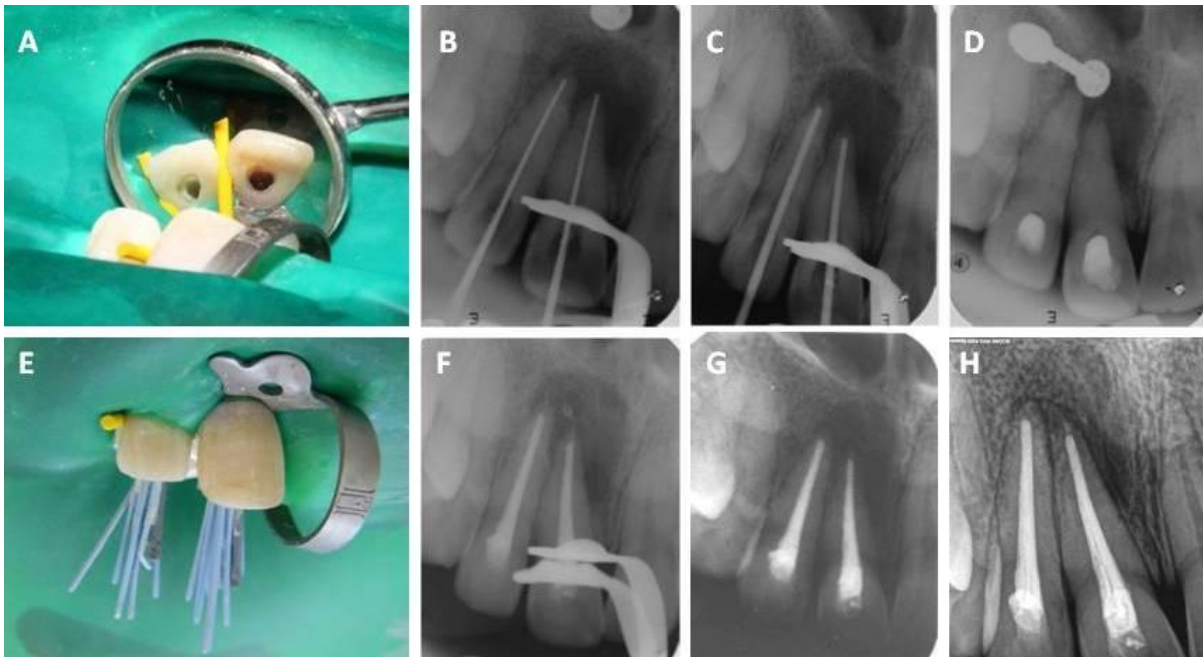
A. Photograph showing access opening done in teeth 11 and 12 under rubber dam isolation; B. IOPA radiograph showing working length determination; C. IOPA radiograph showing master cone determination; D. IOPA radiograph showing intracanal medicament placement; E. Photograph showing obturation done by lateral condensation technique; F. Post-obturation IOPA radiograph; G. 1 month follow-up IOPA radiograph showing reduced size of the periapical lesion in relation to 11 and 12; H. 6 months follow-up digital radiograph revealing progressive healing of the periapical lesion in relation to 11 and 12.
